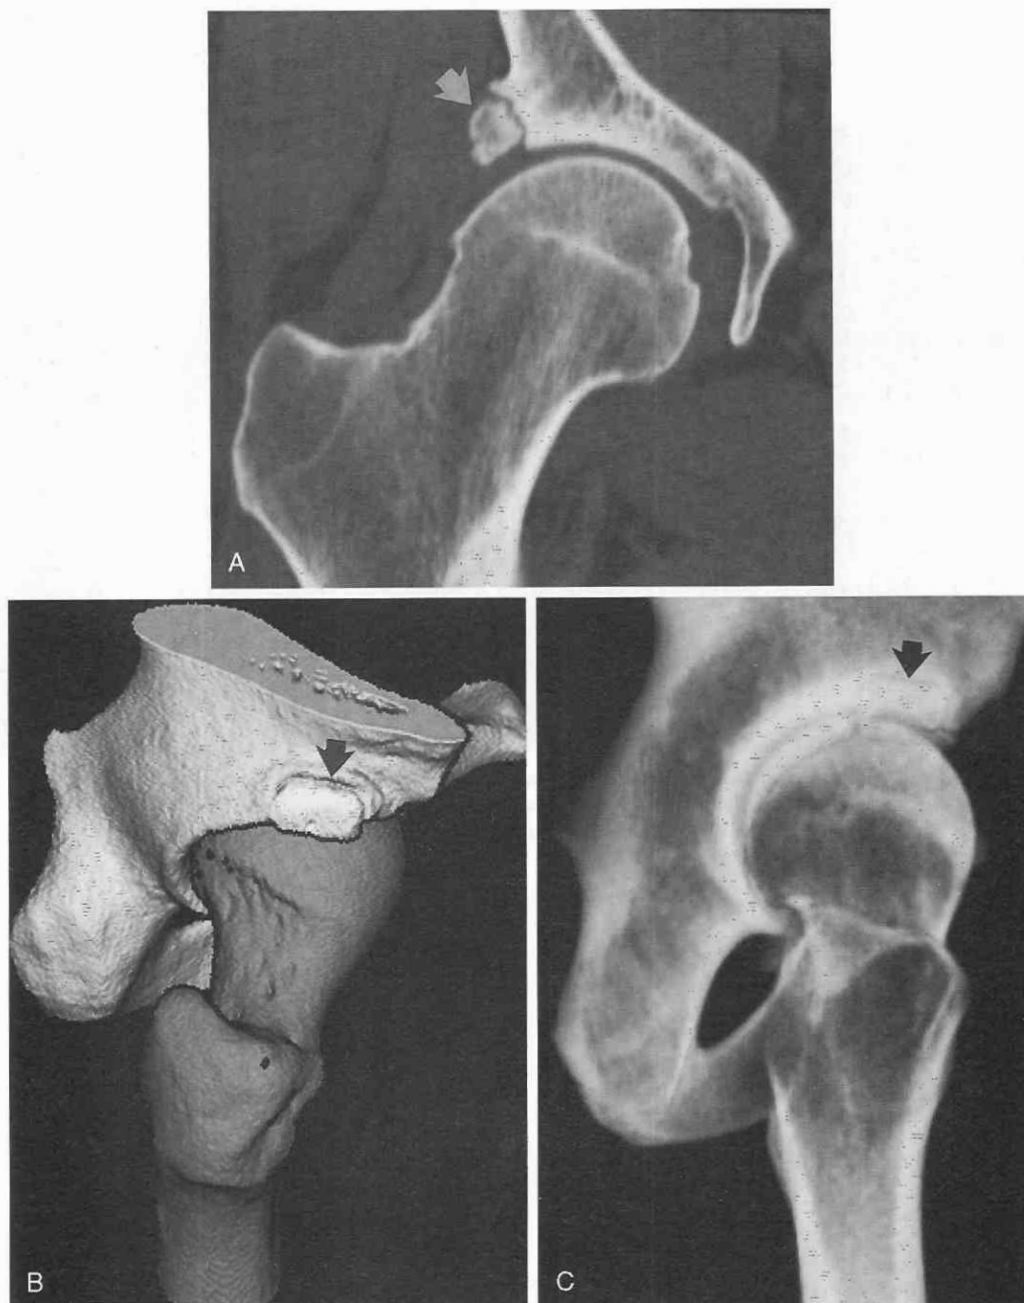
Os acetabuli of a 24-year-old man who complained of right hip pain. Multislice helical CT was performed with 1.0-mm slice thickness. An accessory ossicle (*arrow*) with sclerotic margins is shown on coronal reformat image (*A*), 3D surface shaded display image (*B*), and volume-rendered image (*C*). The volume rendering is performed with a high degree of transparency, emulating plain radiography.
